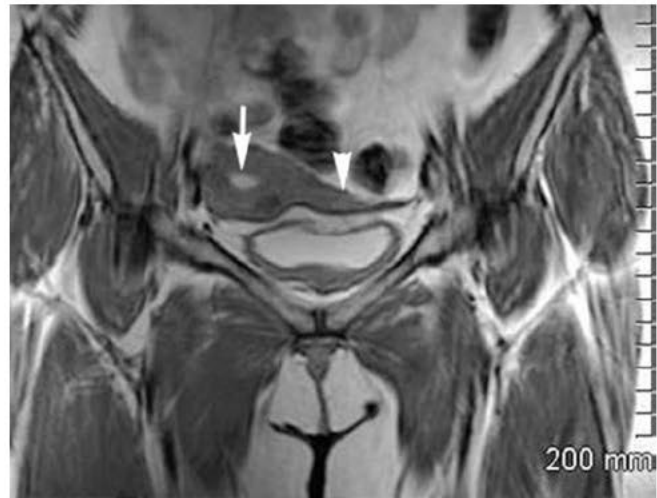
Unicornuate uterus. This coronal T2-weighted image demonstrates a protrusion of myometrial tissue from the left lateral uterine body (*arrowhead*). It is isointense to myometrium but does not demonstrate normal uterine zonal anatomy. Specifically, endometrium (*arrow*) is noted in the developed right uterine horn but not in the left rudimentary horn.
